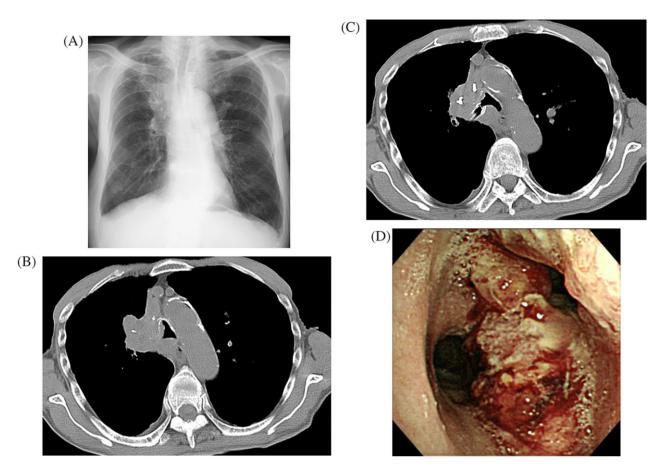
Chest X-ray (A), computed tomography (B, C) and fiberoptic bronchoscopy (D) 6 weeks after the initial stenting demonstrated the severe stenosis of the right mainstem bronchus (C, D), the lower trachea (B, D), and the orifice of the left mainstem bronchus (D).
